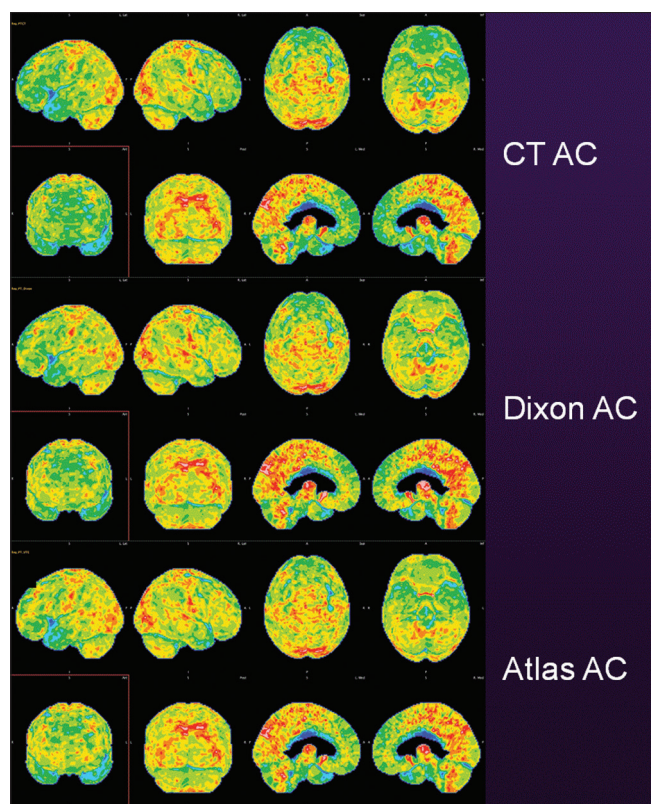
Case example, fused computed tomography from positron emission tomography/computed tomography “gold standard” attenuation correction (top), Dixon-MR-based (middle) and atlas-based attenuation correction (bottom) in a patient with moderate hypometabolism in the frontal, parietal, and temporal lobes bilaterally: AD versus FTD pattern
